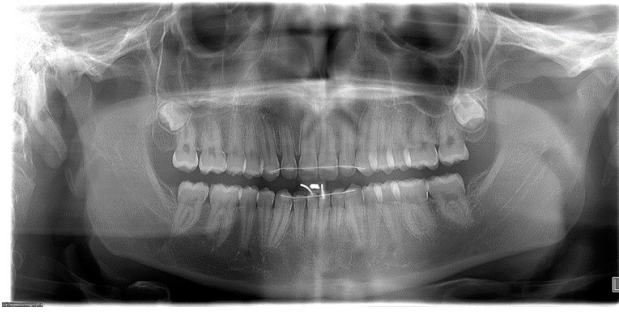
Panoramic radiograph taken 2 years after removal of the orthodontic appliances
